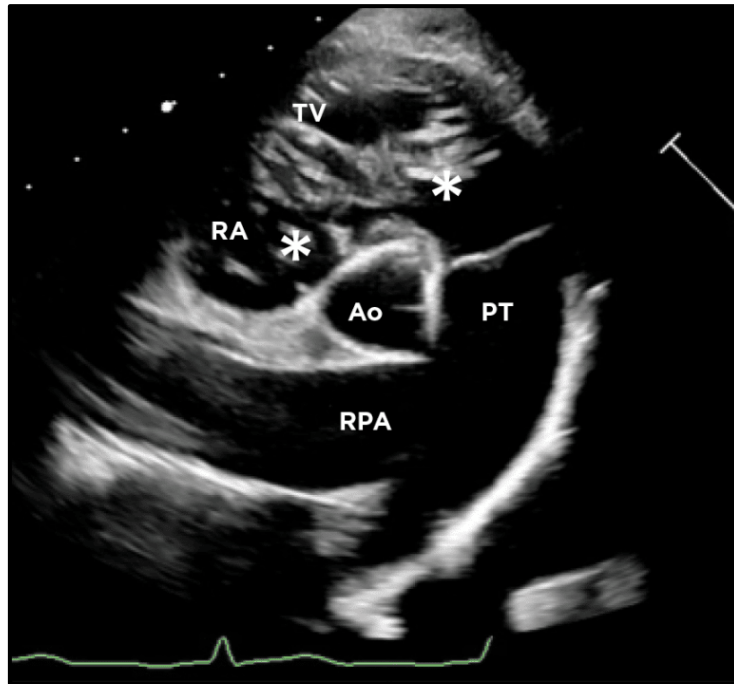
Right parasternal short-axis echocardiographic view showing a mass of heartworms (long and short equal signs; white asterisks) traverses the tricuspid valve [101]
